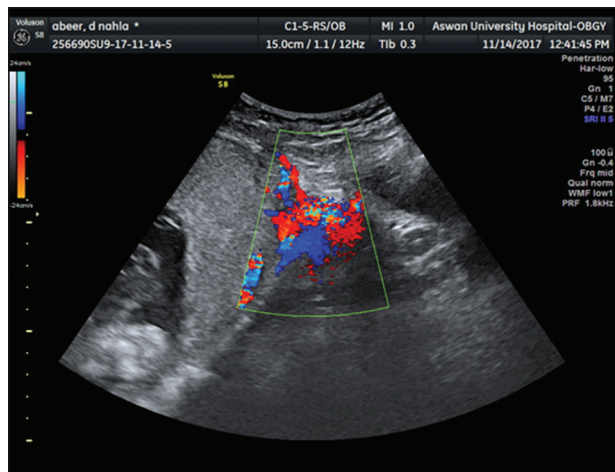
Placenta accreta suspected by Doppler US
